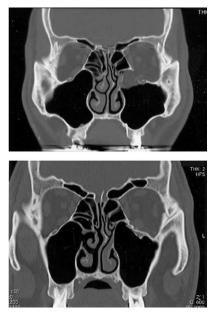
A CT image of a 39-year-old man before operation (upper). The left orbital floor was punched-out and the orbital content with the inferior rectus muscle was herniated to the maxillary sinus. A CT image 8 months after operation (lower). The floor was reconstructed with the calvarial bone graft. CT, computed tomography.
